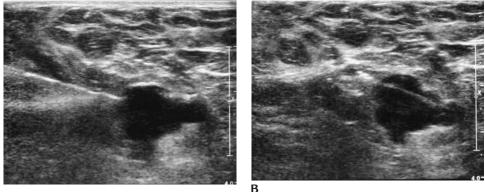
Ultrasound-guided core biopsy. Invasive ductal carcinoma. (A) Pre-fire image demonstrating needle (*double headed arrows*) positioning at the leading edge of a vertically oriented, markedly hypoechoic mass. In this patient, an artery (*arrow*) is seen adjacent to the more superficial aspect of the mass. When arterial structures are seen in close proximity to the area being biopsied, doppler is used to help direct the advancing needle (e.g., to avoid the artery). If the needle is advanced parallel to the transducer as in this patient, it can be seen in its entirety and directed towards portions of the mass away from the adjacent vessel. (B) Post-fire image. The needle is seen through the mass (*double headed arrows*) but deep to the artery (*arrow*).
